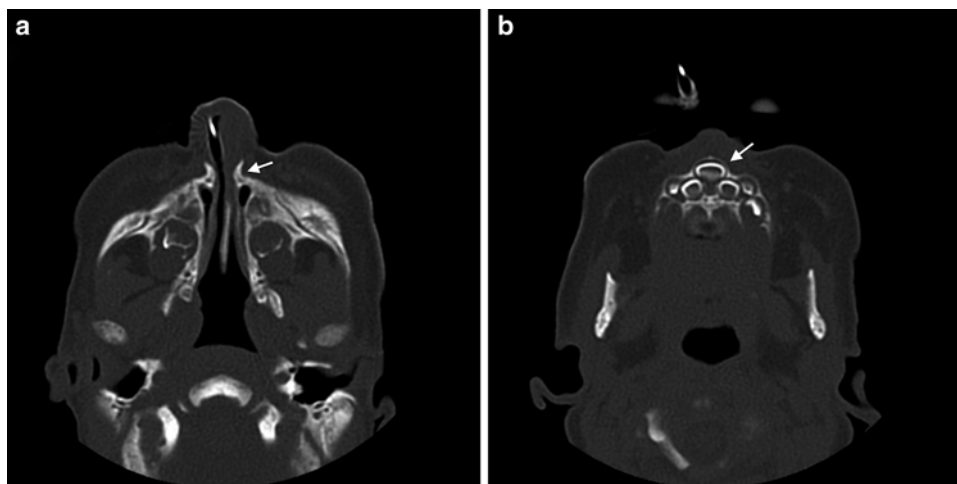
Congenital nasal pyriform aperture stenosis (CNPAS). (a) Axial computed tomographic (CT) image showing a narrow 4 mm pyriform aperture width. (b) Concurrent single central maxillary incisor
